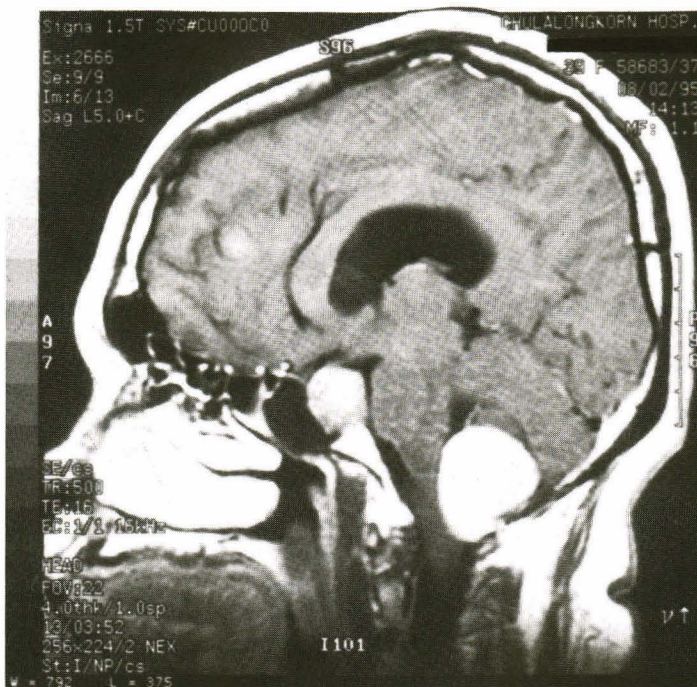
Magnetic resonance images demonstrate prolactinoma metastases in the frontal lobe and the cerebellum with local recurrence in sella turcica (A and B)
